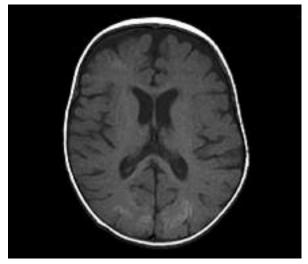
SE/T1 weighted MR images – high intensity of signal areas seen in cerebral cortex of right frontal and both occipital lobes indicative of passive hyperaemia of the cortex.
